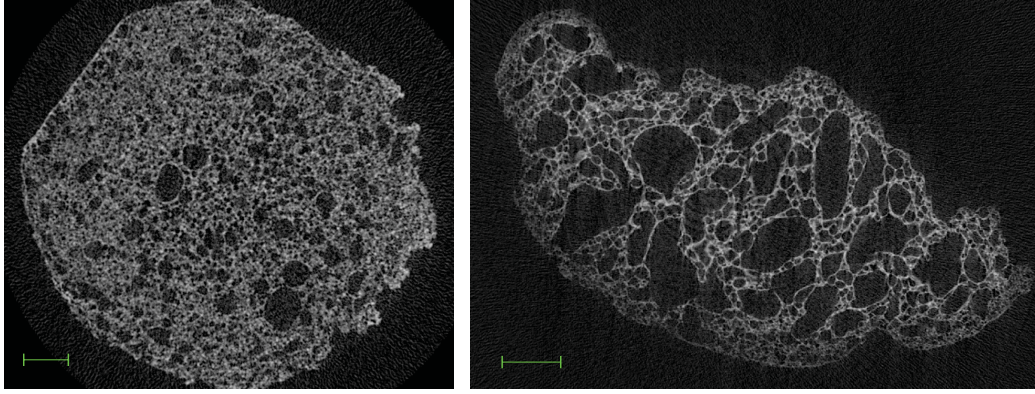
X-ray μ -CT images of DF with PWC 17% (N5 (N13)) (left) and 25% (N6 (N14)) (right) using the VBT. Scale indicated in green equals 1 mm.
